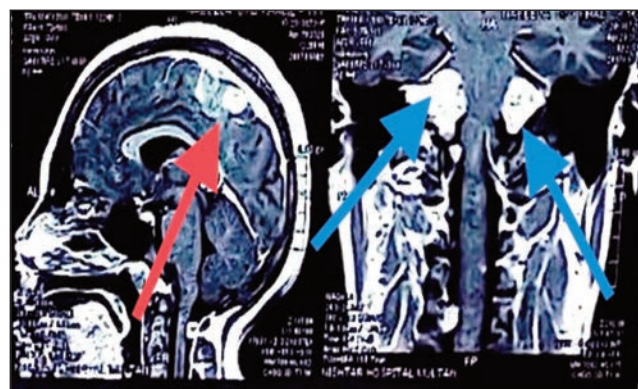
Interhemispheric Meningioma: Red arrow; Bilateral Cerebellopontine angle schwannomas: Blue arrows; T2W MRI.
